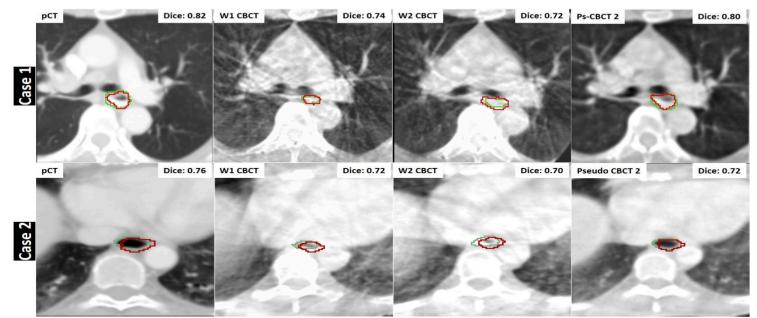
pCT, week1 and week2 CBCTs along with their best ps-CBCT are shown for two typical cases. For each case, green and red contours are ground-truth and segmented esophagus contours, respectively.
